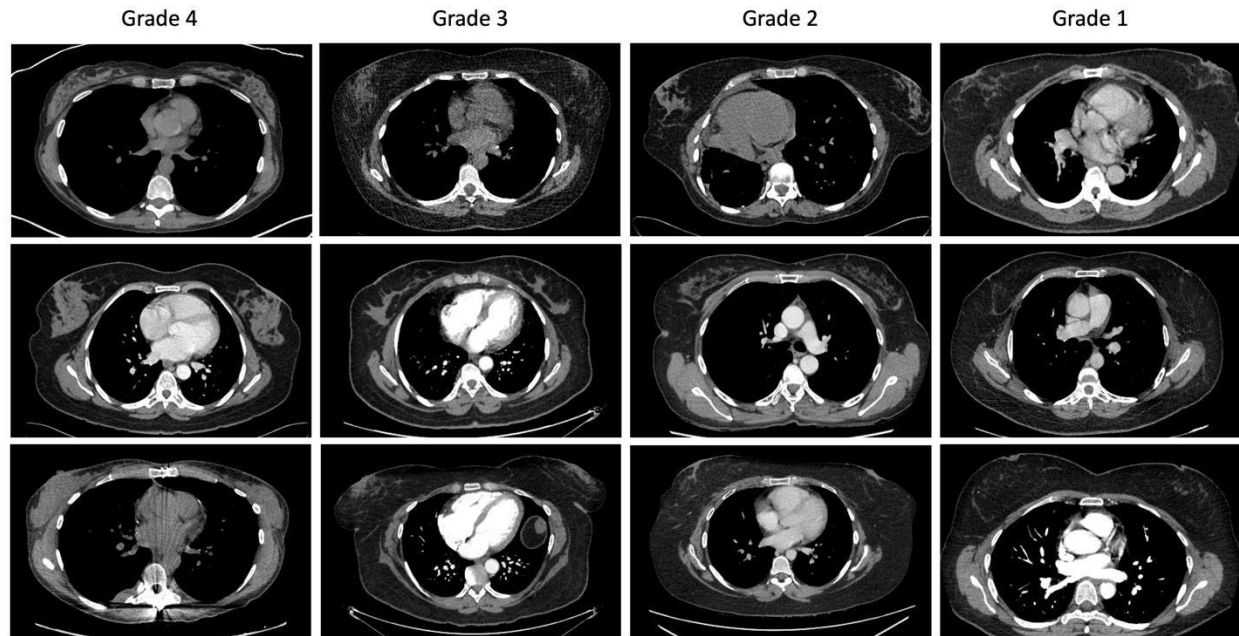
Representative axial slices of chest CT scans from a clinical dataset acquired at Columbia University Irving Medical Center, arranged in columns by breast density grade from highest (grade 4) to lowest (grade 1).
